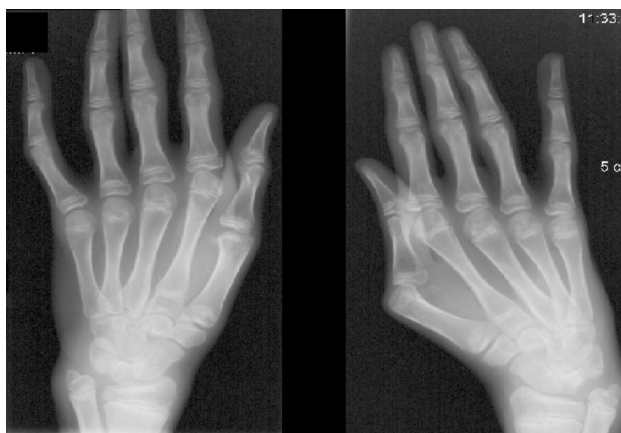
Anteroposterior hand radiograph showed arachnodactyly, wrist drop.
